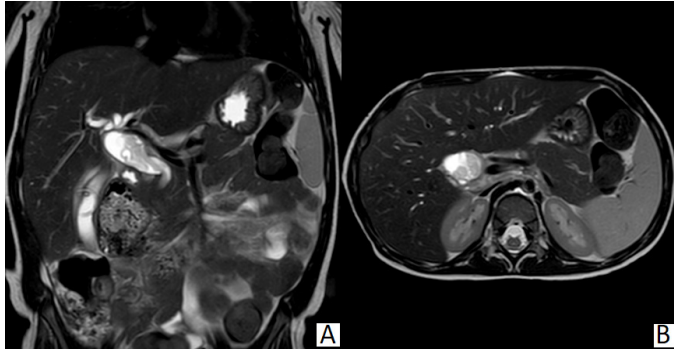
Coronal (A) and axial (B) MRI scans performed in our Department show dilation of the biliary tree and heterogeneous filling defect in the lumen of the choledochus (arrow) characterized by solid component.
